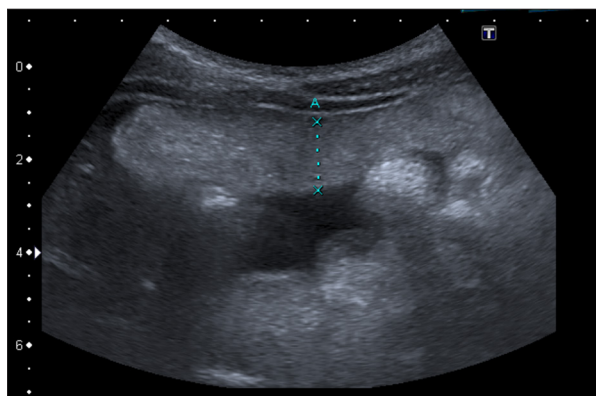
Abdominal ultrasound shows thickening of the greater omentum marked with clips. There is also anechoic free fluid between the small intestines.
